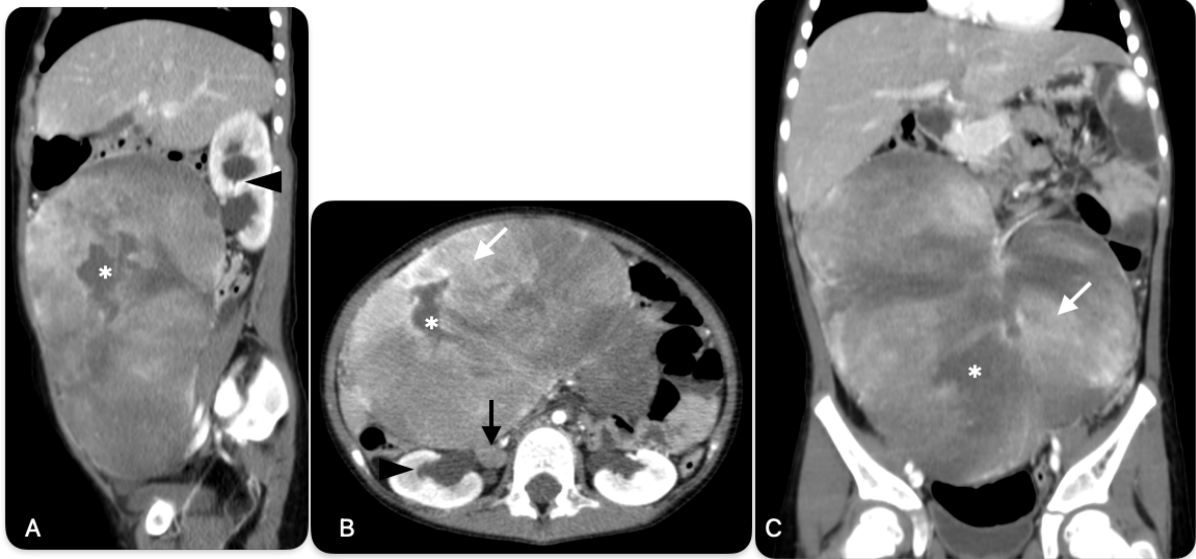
Contrast-enhanced abdominal-pelvic CT scan with multiplanar reconstruction: A (sagittal section), B (axial section), and C (coronal section) show a large retroperitoneal mass with locoregional mass effect, heterogeneous with areas of necrosis (*) and intermediate contrast enhancement (white arrow) and heterogeneous in the rest of the lesion, compressing the ureters and causing right hydronephrosis and exerting a locoregional mass effect (black arrowhead). B. There are suggestive secondary adenopathies (black arrow)
